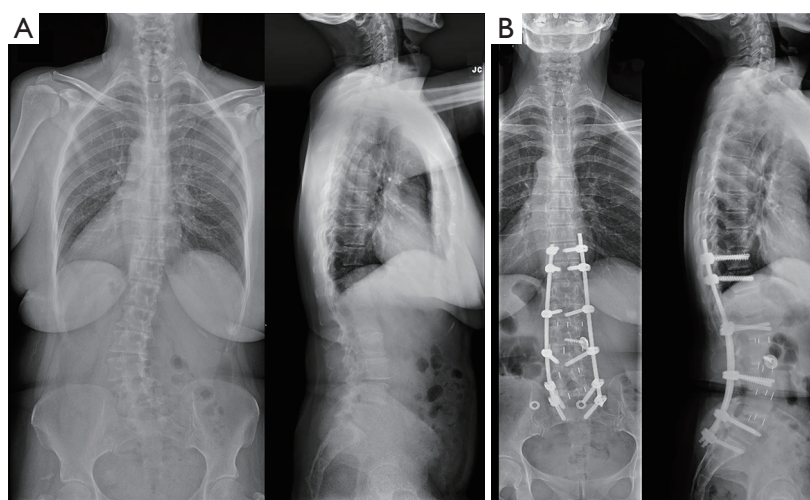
Patient case with transitional anatomy undergoing MIS-ATP + PPF. (A) Preoperative anteroposterior view (left) and lateral view (right) X-rays demonstrating lumbarized S1 transitional anatomy. (B) Postoperative anteroposterior view (left) and lateral view (right) X-rays demonstrating long spinal fusion with four points of sacral fixation. MIS-ATP, minimally invasive surgery antepsoas; PPF, posterior percutaneous fixation.
